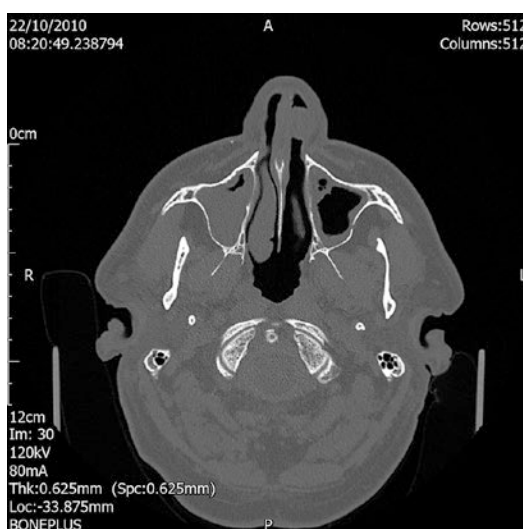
Axial CT scan of the paranasal sinuses demonstrating a soft tissue lesion arising from the left side of the nasal septum
